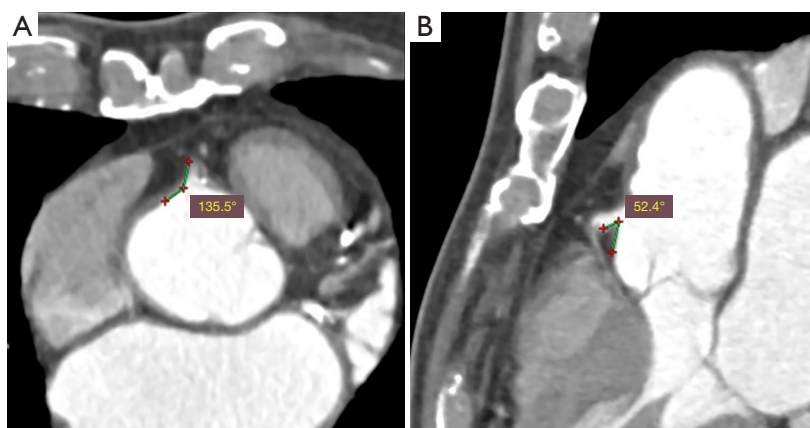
CCTA images demonstrating the significant discrepancy of using axial images for measuring RCA-aorta angle when compared to that measured on MPR views. (A) RCA-aorta angle of 135.5° measured on 2D axial view. (B) RCA-aorta angle from the same CCTA dataset measured at 52.4° on MPR. CCTA, coronary computed tomography angiography; RCA, right coronary artery; MPR, multiplanar reformation.
